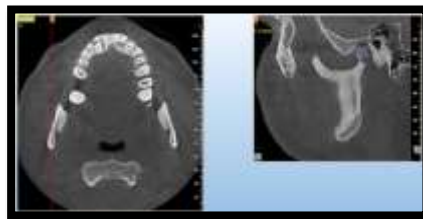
Measurement of condylar length and height in right side of 37 years old male on CBCT in sagittal section.
